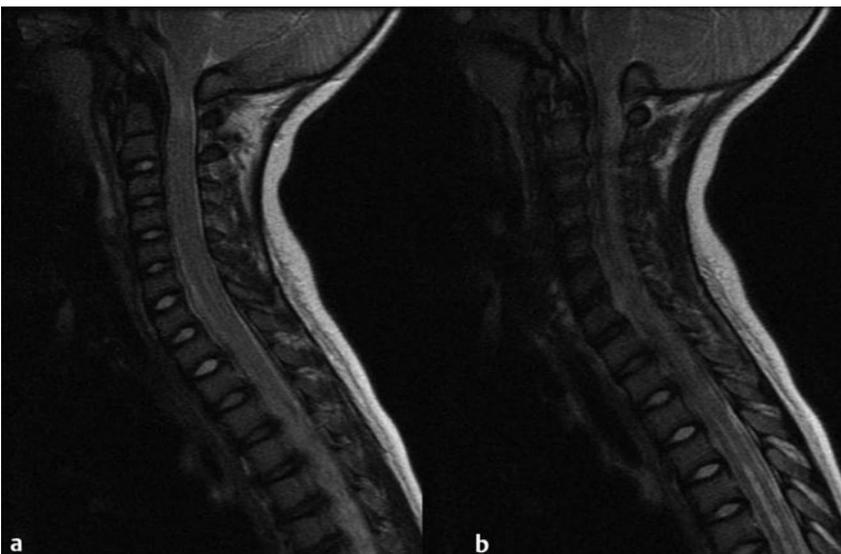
(a) Infant with achondroplasia who presented with craniocervical stenosis and upper cervical signal abnormality on T2-weighted images, indicating cord compromise at that level. (b) Note the associated syringomyelia in the low cervical and upper thoracic region.
